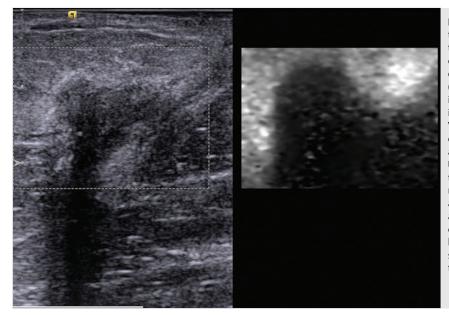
An ARFI pulse creates two types of tissue motion, the displacement of the tissue and the generation of shear waves. When the displacement is tracked, a strain elastogram is obtained. This is an example of an SE elastogram (so only relative stiffness values are displayed) of invasive ductal cancer using Virtual Touch imaging (VTI, Siemens Ultrasound, Mountain View, CA). As opposed to SE using the manual compression technique, the FOV has a maximum allowable size and is placed to include the lesion. Using a very light touch with the transducer on the breast, the patient is asked to remain still and not talk while the update button is pressed to activate the ARFI pulse. The system will freeze for a few seconds and then the VTi image will be displayed. The grayscale map is used here with black as stiff and white as soft. The lesion is significantly stiffer than the surrounding breast tissue.
